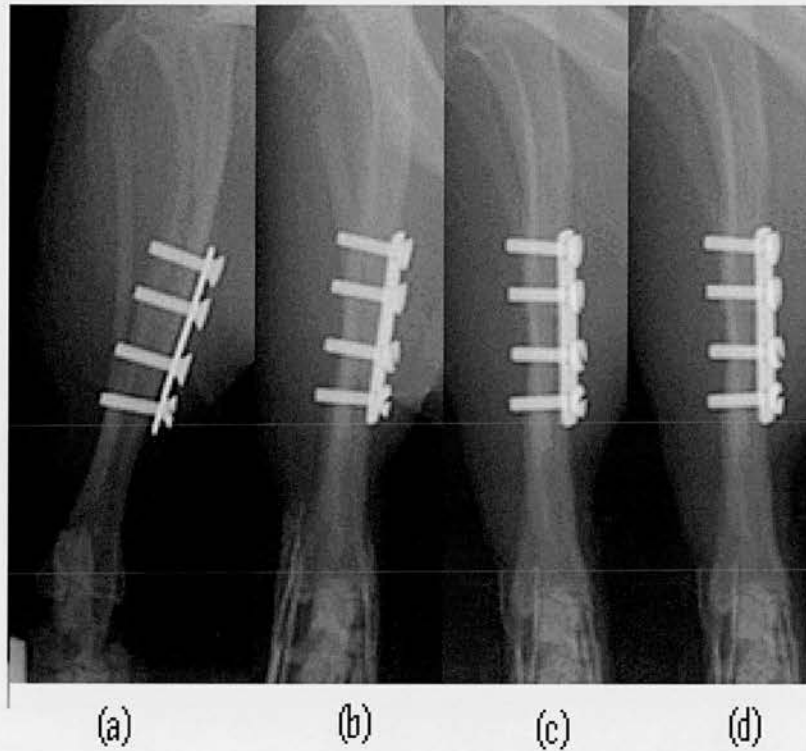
(a) A-P radiograph of plated tibia. (b) Valgus stress. (c) Varus stress. Note no widening or translation of osteotomy on stress application.
